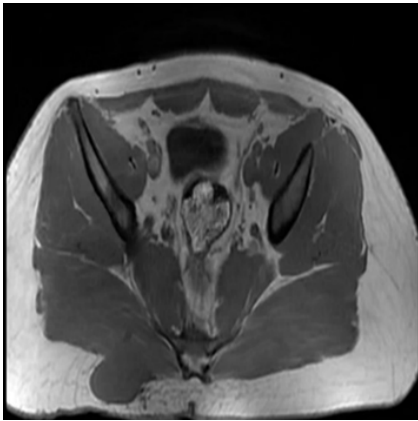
MRI T1WI image.
